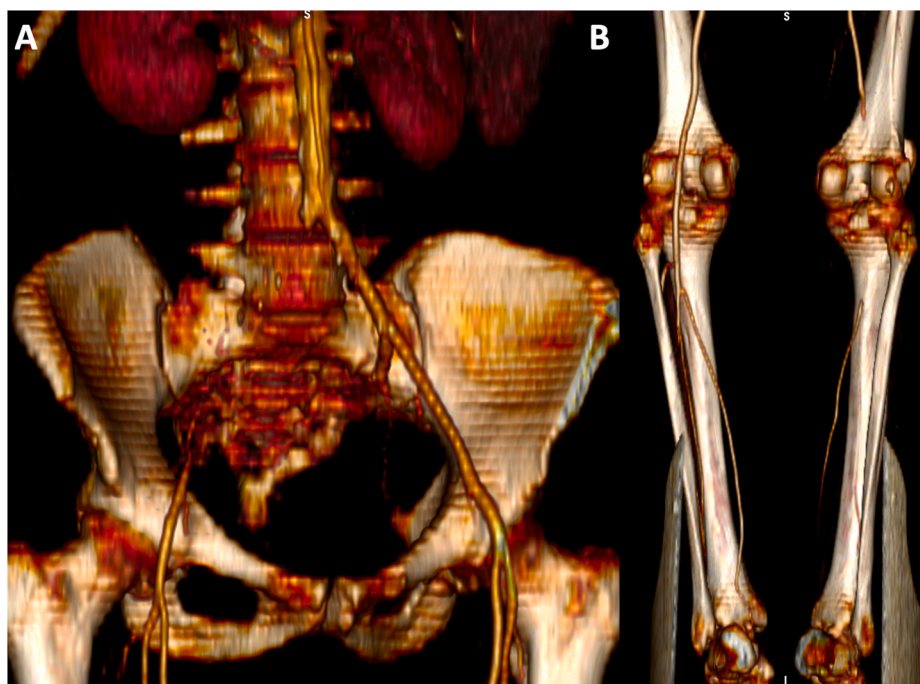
CTA three-dimensional reconstruction showing complete thrombotic occlusion of the right iliac axis, with patent common femoral artery (A, anterior view), and popliteal artery occlusion with only posterior tibial artery partial rehabilitation (B, posterior view).
